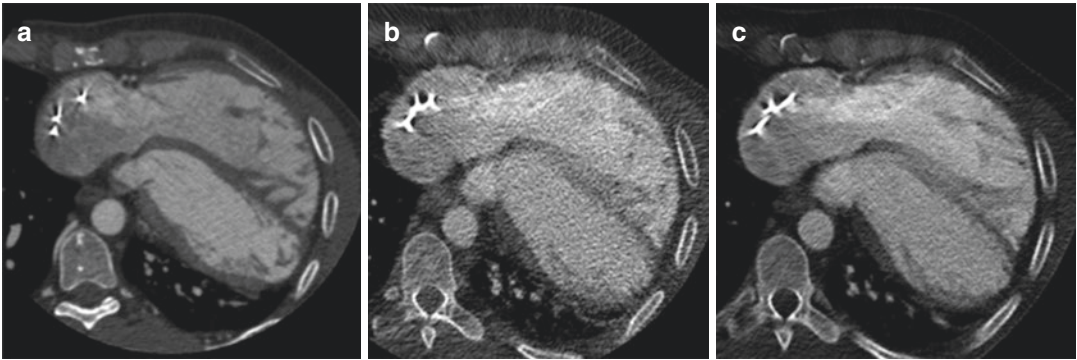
Decreasing dose in cardiac CT through kV manipulation. (a) Axial cross section by CT in 2008 in a patient with tetralogy of Fallot acquired at 0.5 mm, 120 kV, multiphase. Image quality is excellent with little noise but the total effective dose was 25 mSv. (b) Same patient re-imaged in 2010 at 0.5 mm, 80 kV, multiphase. The image
